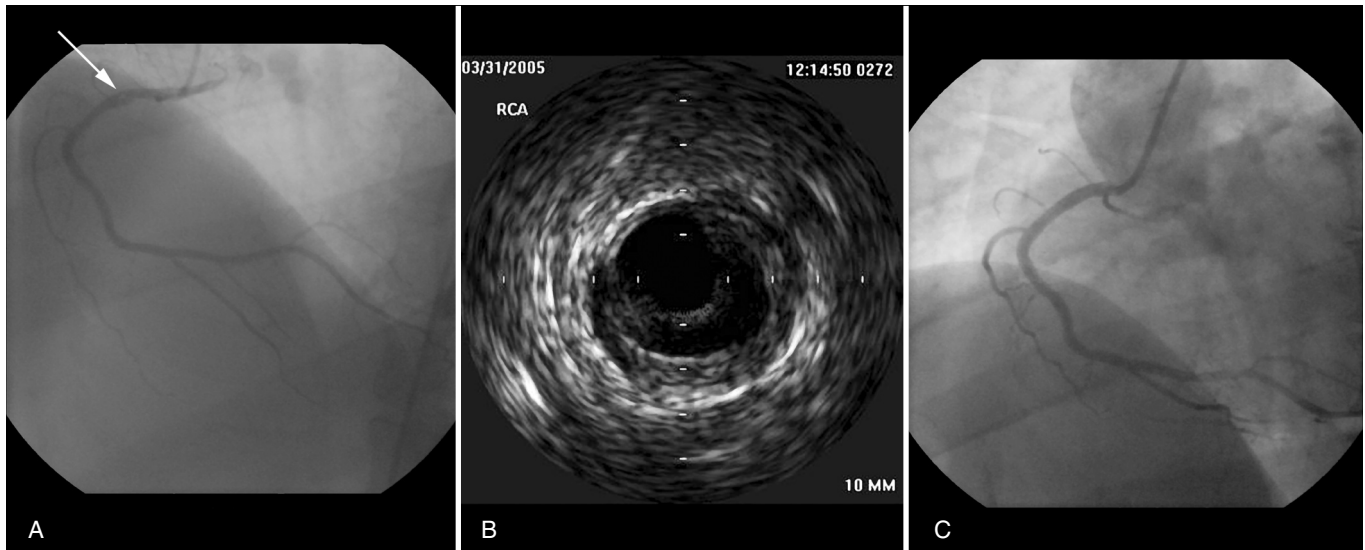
(A) Right coronary artery with a filling defect (arrow). (B) Intravascular ultrasound showing a stenosis with 80% occlusion and a large lipid pool. (C) Right coronary artery following placement of a coronary stent.
